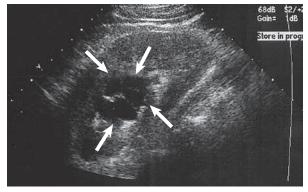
Complex renal cyst (arrows). Sagittal ultrasound image.
